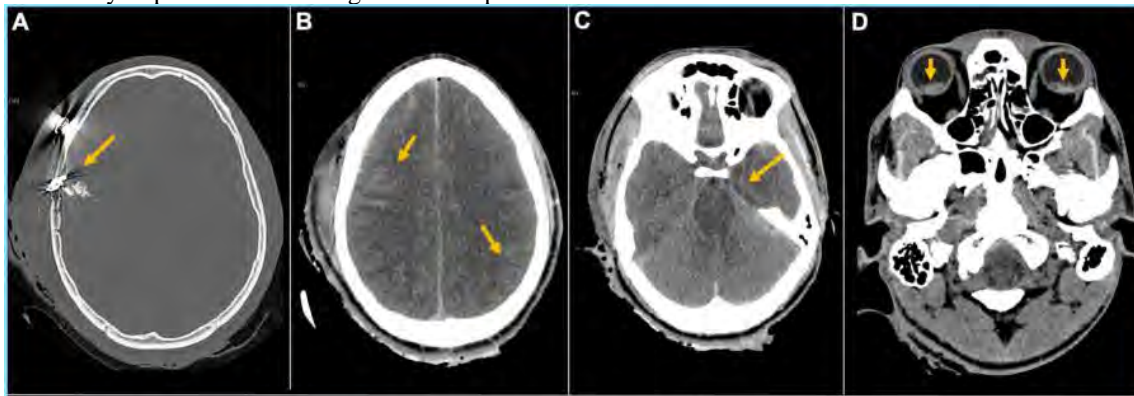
Axial CT bone window showing a gun shot wound to the right frontal bone with comminuted right frontal bone fracture and ballistic fragments (arrow) in the brain parenchyma.
